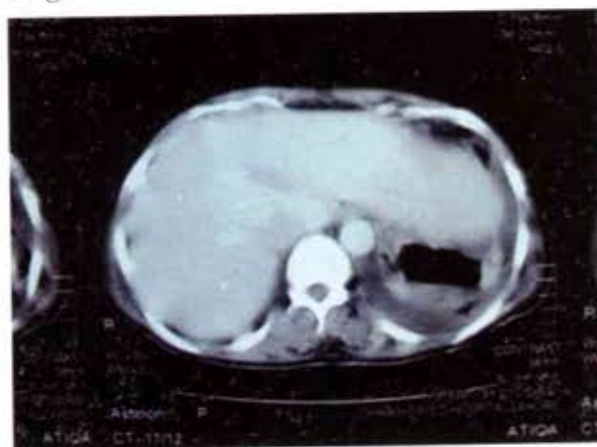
CT abdomen showing ruptured hydatid cyst in lower part of left lung.
